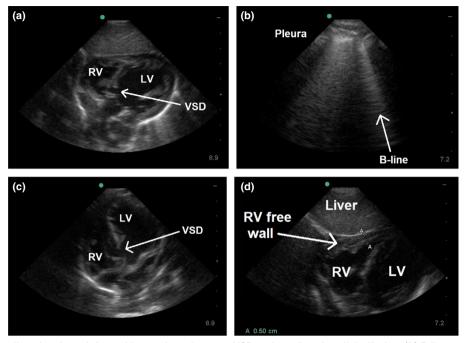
(a) Subcostal cardiac view in an infant with a perimembranous VSD and small pericardial effusion. (b) B lines seen throughout the lungs in an infant with hypoxia and VSD, consistent with pulmonary oedema. (c) Apical four-chamber view in an infant with a perimembranous VSD, 48 h after diuresis commenced, with pericardial effusion now resolved. (d) Subcostal measurement of RV free wall in an infant with VSD and suspected right heart sequelae, 48 h after diuresis commenced.
